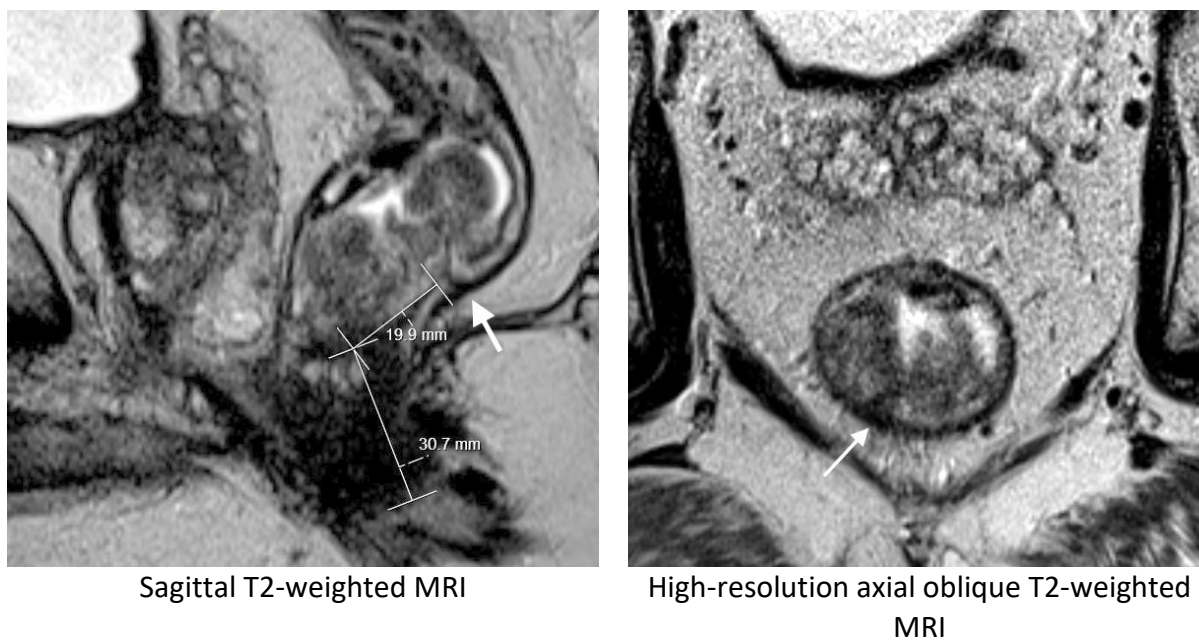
MRI of an early rectal cancer suitable for local excision
